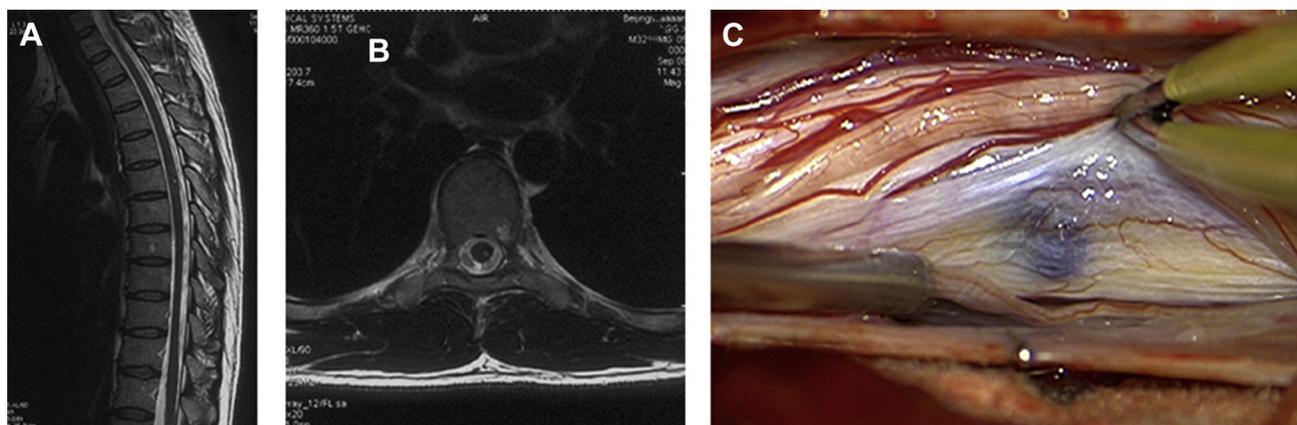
(A) Preoperative magnetic resonance imaging of a patient with intramedullary spinal cord cavernous malformation. (B) The radiography results of this patient were negative. (C) Intraoperative findings.
